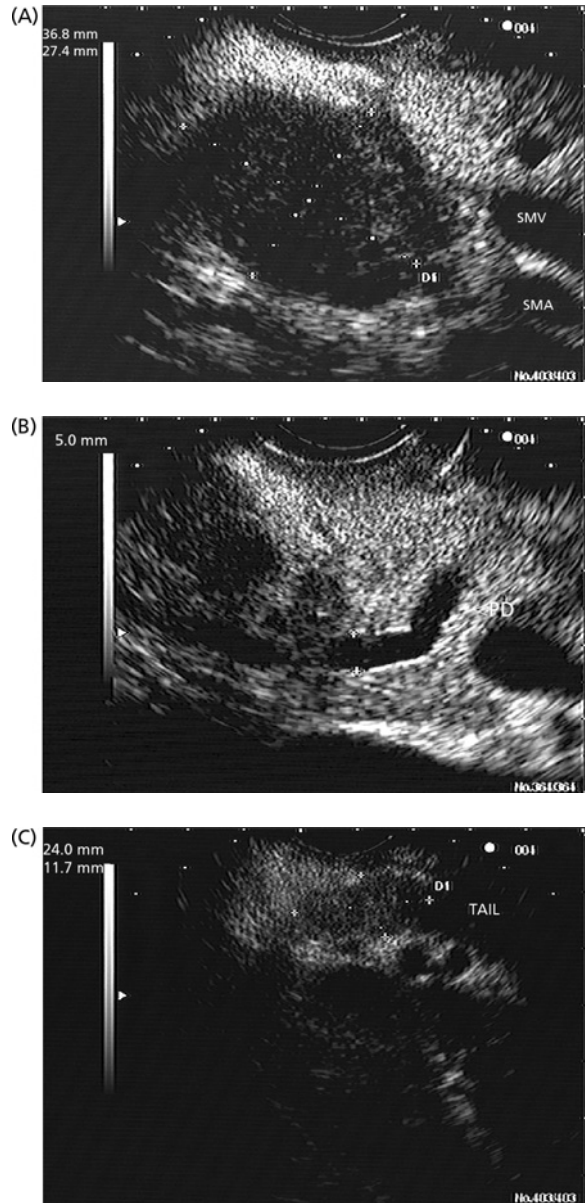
Autoimmune pancreatitis. A focal, well-circumscribed mass was seen in the pancreatic head on CT imaging of a young woman with abdominal pain and elevated lipase. EUS demonstrated a 37 × 27 mm hypoechoic mass in the pancreatic head (A) resulting in upstream pancreatic duct dilation (B). The pancreatic body was relatively normal. A second hypoechoic lesion was seen in the pancreatic tail (C). Needle aspiration of the pancreatic head was performed and interpreted by cytopathology as showing adenocarcinoma. Outside cytology review confirmed the diagnosis, however surgical resection revealed autoimmune pancreatitis without malignancy. This is the only instance of false positive cytology in our experience.
